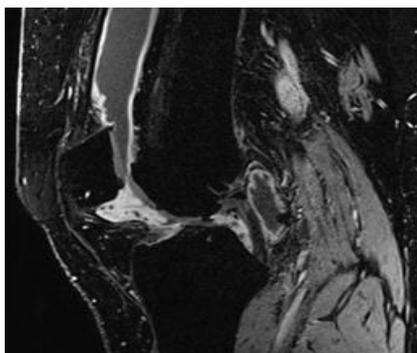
Gadolinium enhanced sagittal T1 weight MRI of a patient with osteoarthritis showing joint effusion and enhanced synovium indicating synovitis
